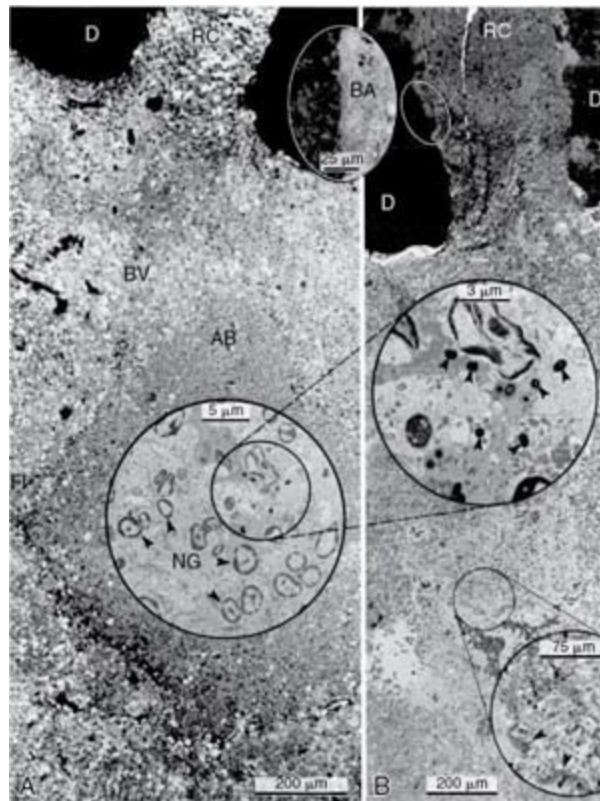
Structure of a secondary periapical abscess. A, Axial section of an abscessed apical periodontitis. The microabscess (*AB*) contains a focus of neutrophils (*NG* inset in A). Note the phagocytosed bacteria in one of the neutrophils (further magnified in large inset in B). A secondary abscess forms when bacteria (*BA* in oval inset) from the apical root canal (*RC*) advance into the chronic apical periodontitis lesion (B). Note the tissue necrosis immediately in front of the apical foramen and the bacterial front in the body of the lesion (*arrowheads in*
